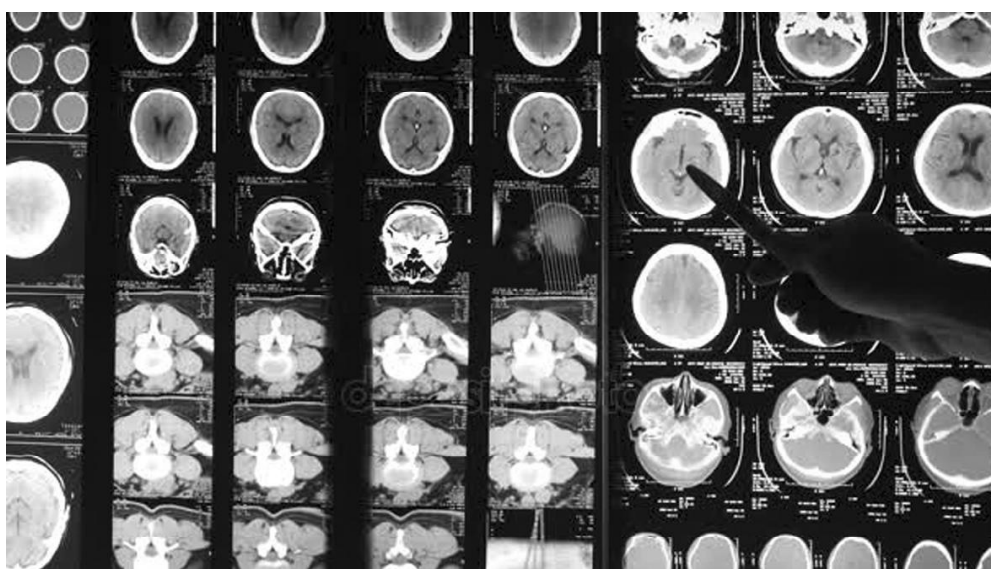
MRI image of a 55-year-old patient with a diagnosis of "acute period of ischemic stroke"
